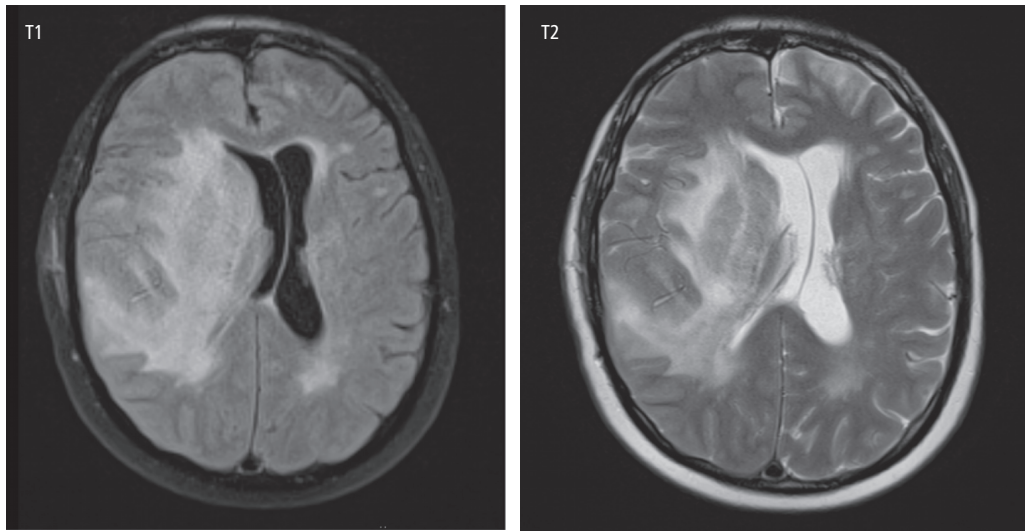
T1 and T2 MRI scan images of a primary cerebral lymphoma mass, showing a large right basal ganglia lesion with midline shift, compression of the right lateral ventricle and peritumoral oedema. In the T1 image the CSF is black (low attenuation) and the bone is white (high attenuation), whilst in the T2 image the CSF is white (high attenuation) and the bone is black (low attenuation).
